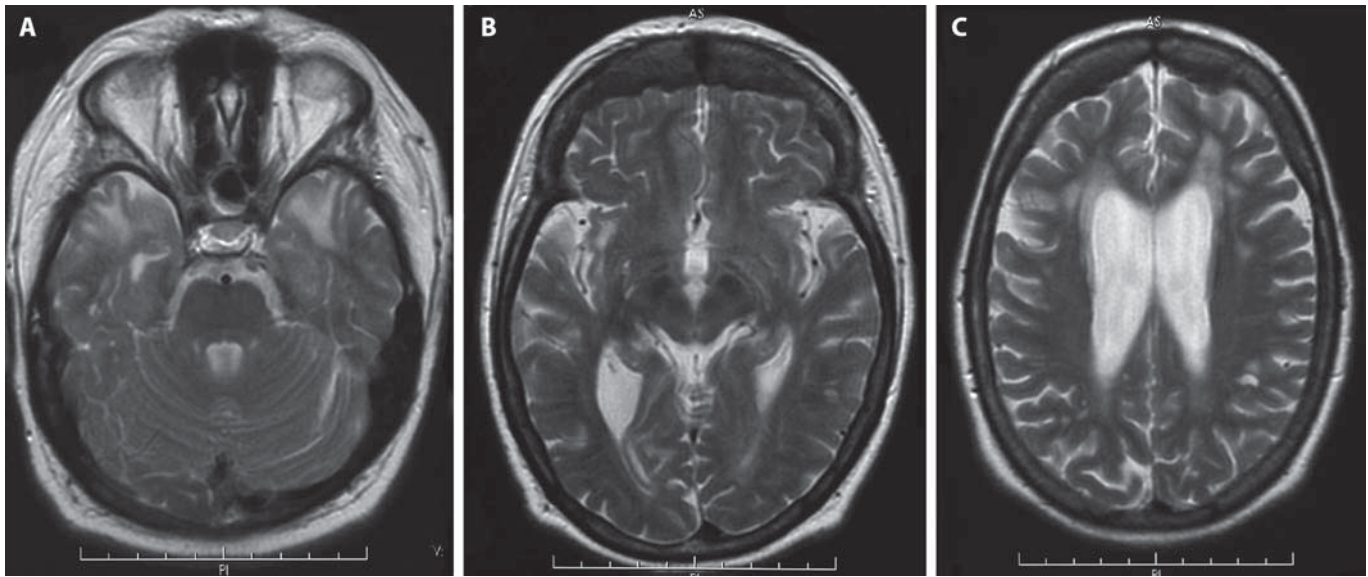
MRI. A, B T₂-weighted MR images demonstrate confluent hyperintense signal alterations in the subcortical white matter of the anterior temporal poles (A) and the capsula extrema (B) bilaterally. C In addition, there are circumscribed hyperintense signal alterations in the subcortical cerebral white matter which are confluent in the frontal regions.
